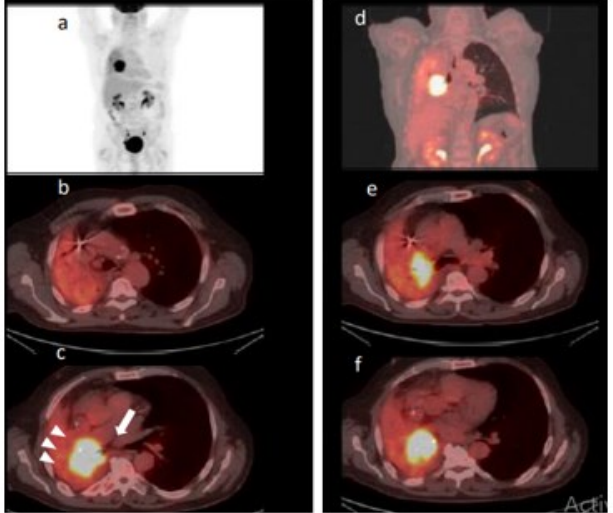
y.o male with right central hypermetabolic tumor, invasion of main bronchus and right lung atelectasis, FDG PET CT can discriminate well between viable tumor (arrow) and atelectasis (arrowheads).
